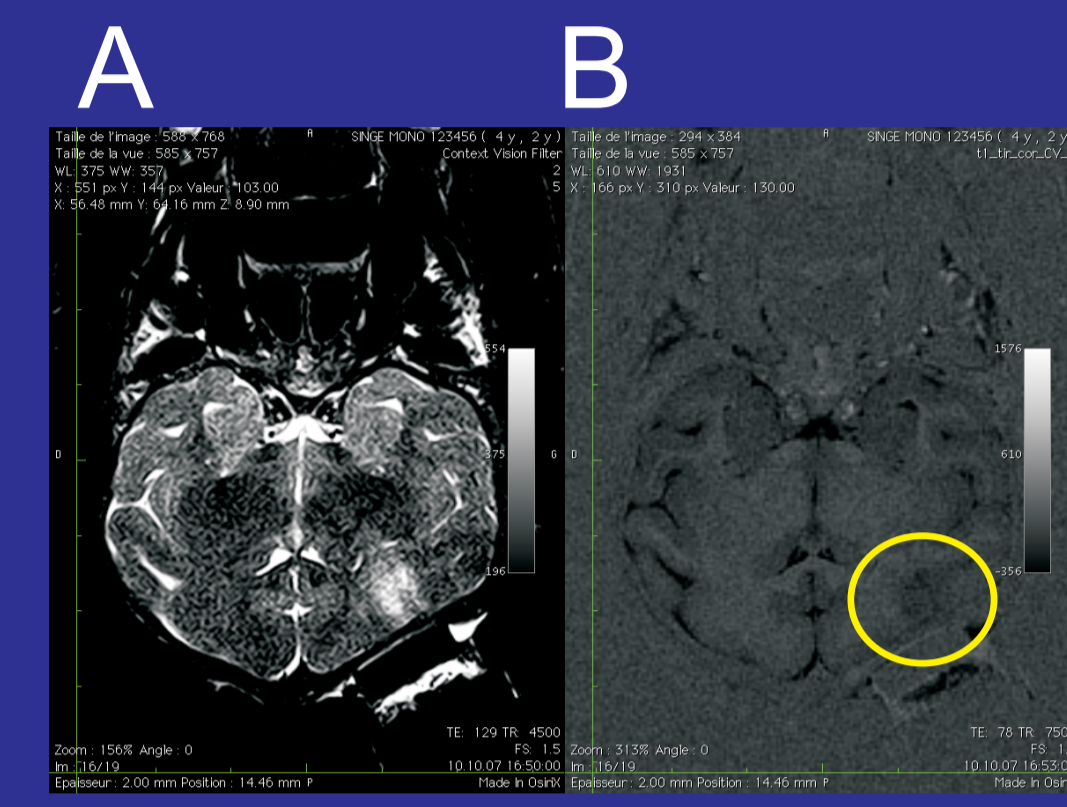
MRI showing the localisation of the lesion (A) in Mk-AM in another acquisition protocol B, yellow circle
